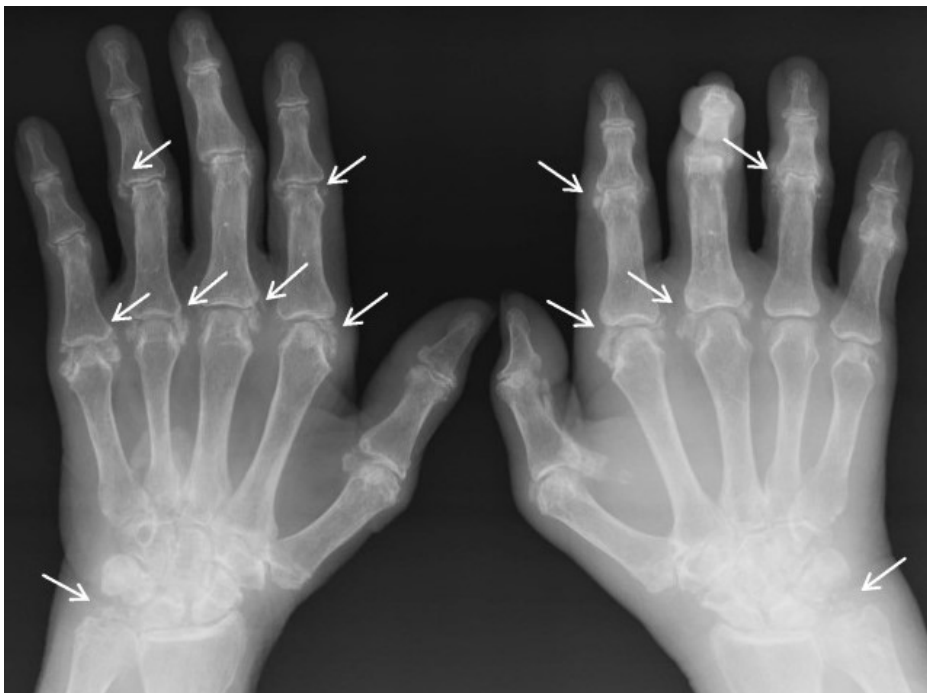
X-ray of the hand demonstrating CPPD involving the multiple hand joints and ulno-carpal joint (white arrows).
